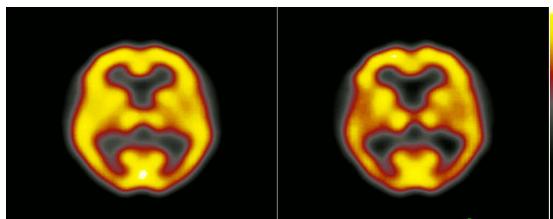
Mean SPECT images of 6 SMI patients (left) and 8 AD patients (right).
